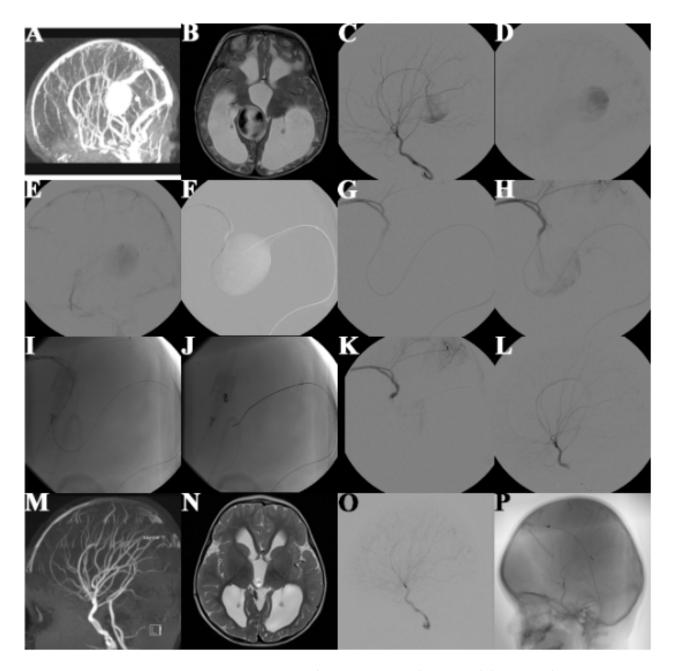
Neurointerventional Treatment–Hemodynamic Stabilization with One-stage Transvenous Embolization in a 4-month-old Patient with VGM Lasjaunias Type 2 "Mural". Note: one-stage transvenous retrograde embolization ("looping technique" and "wedging technique") with subsequent neurological improvement; (A,B) MRI before embolization showing single arteriovenous fistulas and venous outflow via the dilated MPV; (C–E) angiography of the arterial feeders (posterior pericallosal artery); (F–I) one-stage transvenous retrograde embolization from one strategic target with coils; (J–L) angiography after embolization with confirmation of obliteration of the arteriovenous fistula and complete elimination of the shunt volume; (M–P) unremarkable MRI at 23-month follow-up.
